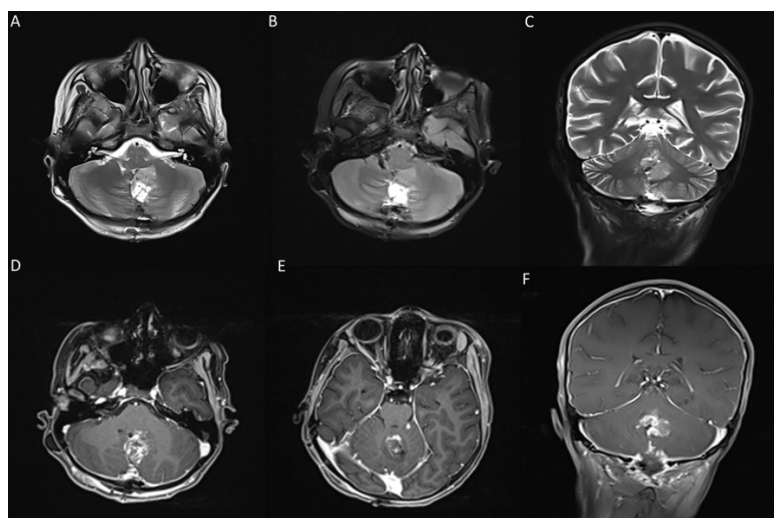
MRI following the second surgical resection.
